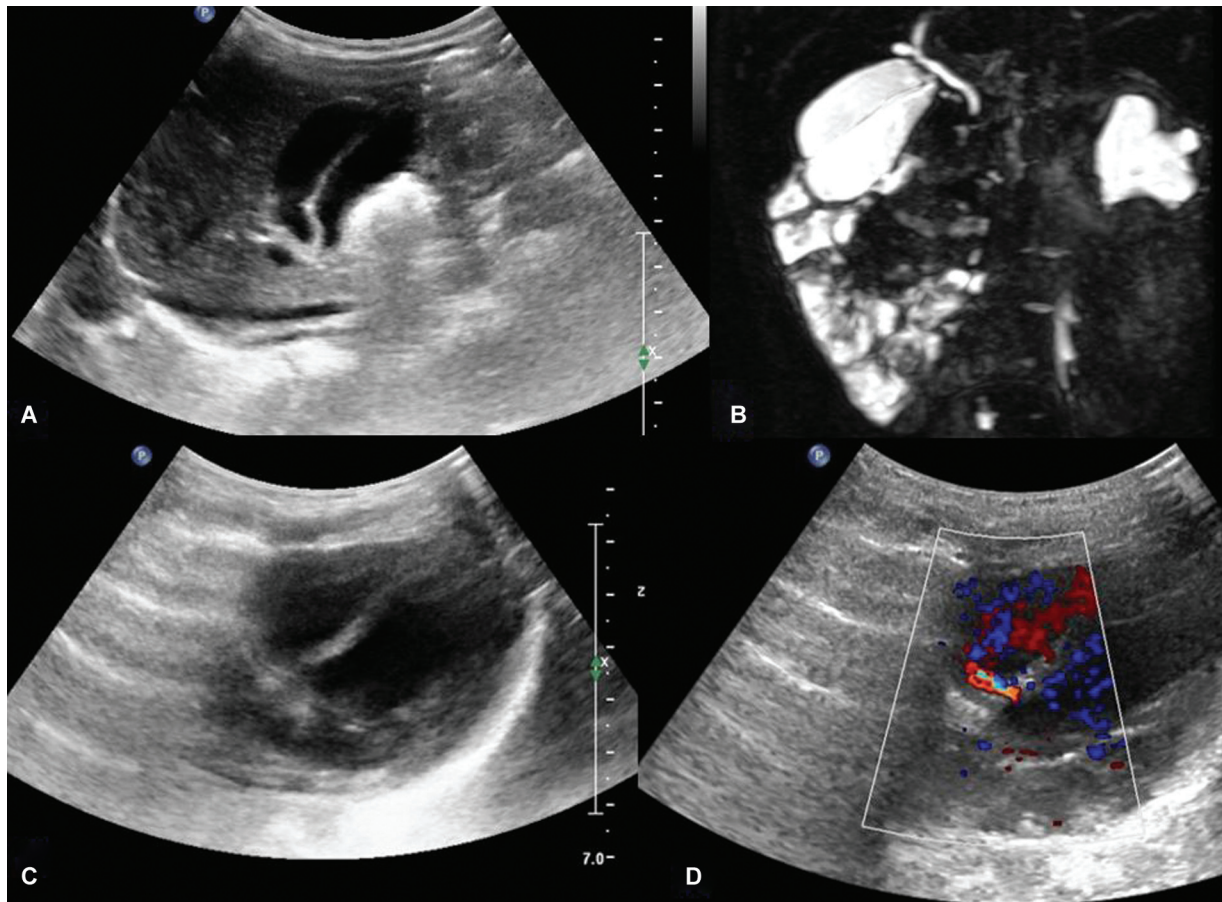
(A) Transabdominal ultrasound (USG) showing two elongated saccular structures of anechoic content at the gallbladder fossa, reflecting duplicated gallbladder. (B) Coronal magnetic resonance cholangiopancreatography (MRCP) images showing two pear-shaped structures in the gallbladder fossa suggestive of duplicated gallbladder with common cystic duct draining into the common bile duct (CBD). Left-sided pelvic-ureteric junction (PUJ) obstruction is also seen. (C, D) USG and Doppler images showing presence of ventricular septal defect.
